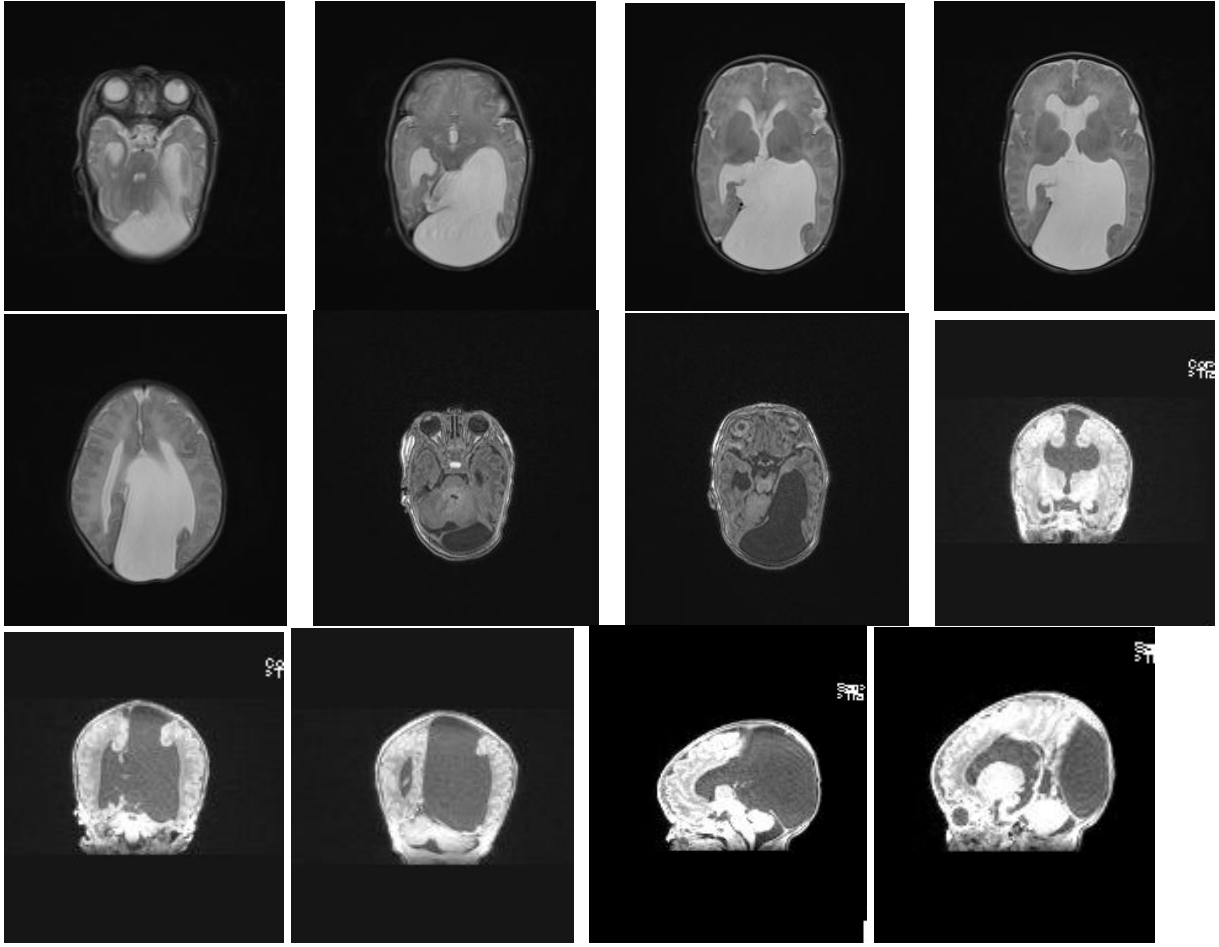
Giant interhemispheric cyst associated with the left ventricle and subarachnoid space on postnatal MRI coronal, axial and sagittal sections.
